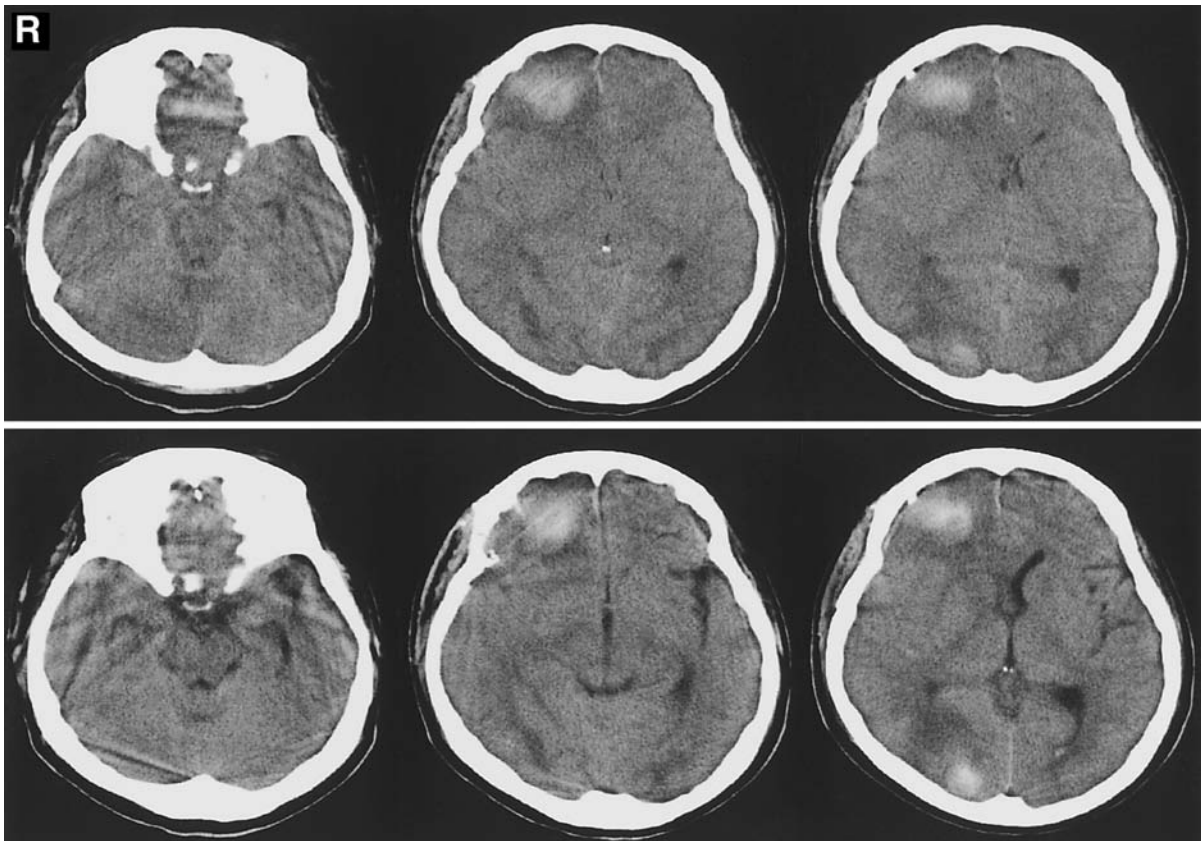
Computed tomography scans performed immediately following the convulsive seizure that occurred 15 days after the first hemorrhage revealing massive cerebral swelling (upper row) that was no longer apparent the next day (lower row).
